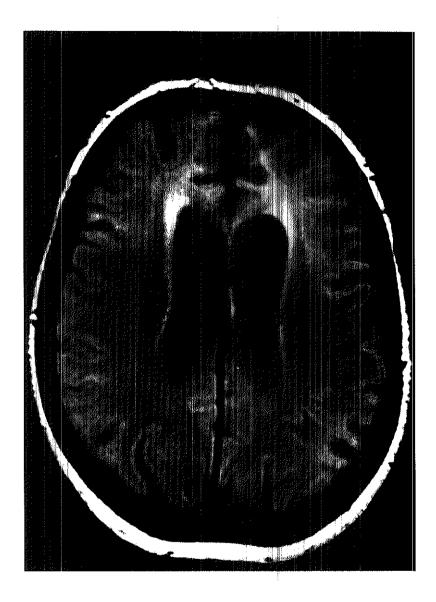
MRI scan of a patient from family I showing increased signal intensities in the subcortical white matter of the frontal lobe on T2-weighted images.
